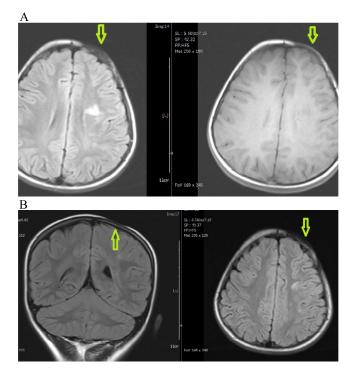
(A and B) Left upper; coronal T2 FLAIR image, right upper; axial T2 FLAIR image, left lower; axial T2 FLAIR image, right lower; axial T1 weighted image, respectively. Images demonstrate a focal area of scalp thinning within the left frontoparietal region with associated flattening and thinning of the underlying frontal and parietal bones (yellow arrow).
